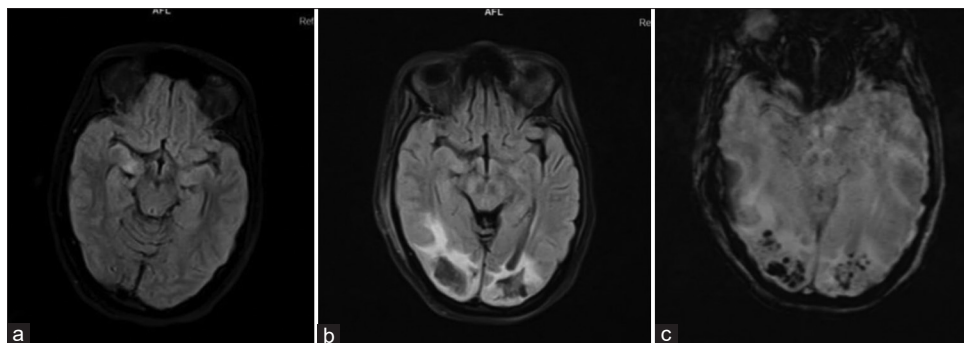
(a) T2 FLAIR suggestive of bilateral medial temporal pole (right > left) hyperintensity. (b) T2 flair shows bilateral medial occipital white matter heterogenous hyperintensity without mass effect. (c) SWI image shows punctate hemorrhagic foci in bilateral occipital lobe
